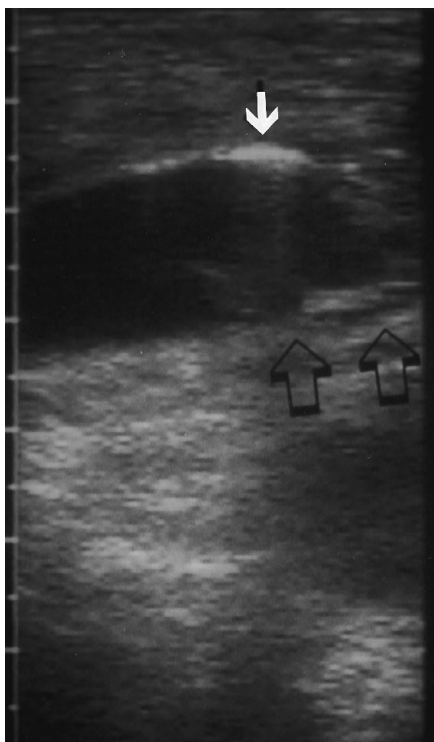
Longitudinal gray-scale sonogram of the common carotid artery (CCA). The caliber of the CCA is larger in the more cephalad portion of the vessel and there is an irregularity of the posterior wall (*open arrows*). At surgical exploration there was a posterior wall laceration requiring an interposition graft. Also note the hyperechoic foci with posterior shadowing along the anterior wall of the CCA (*solid arrow*), denoting air within the carotid sheath.
